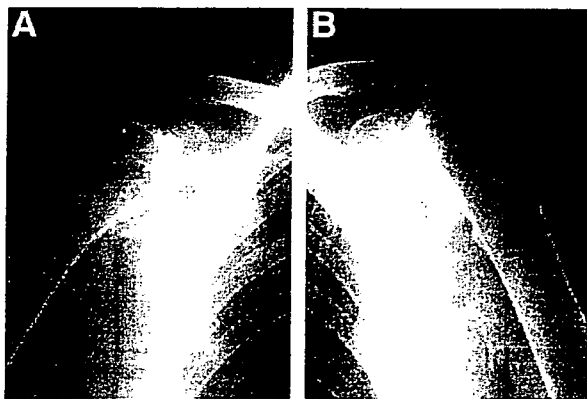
A and B, Radiographs of the rheumatoid shoulders of a 61-year-old woman show bilateral grade 5 glenohumeral joint destruction (GHD), and a mild grade of greater tuberosity destruction. Both shoulders showed extensive erosive destruction of articular surface, both osseous lesions of the greater tuberosity were mild. The destruction pattern was symmetric GHD type. The destruction was symmetrical.
